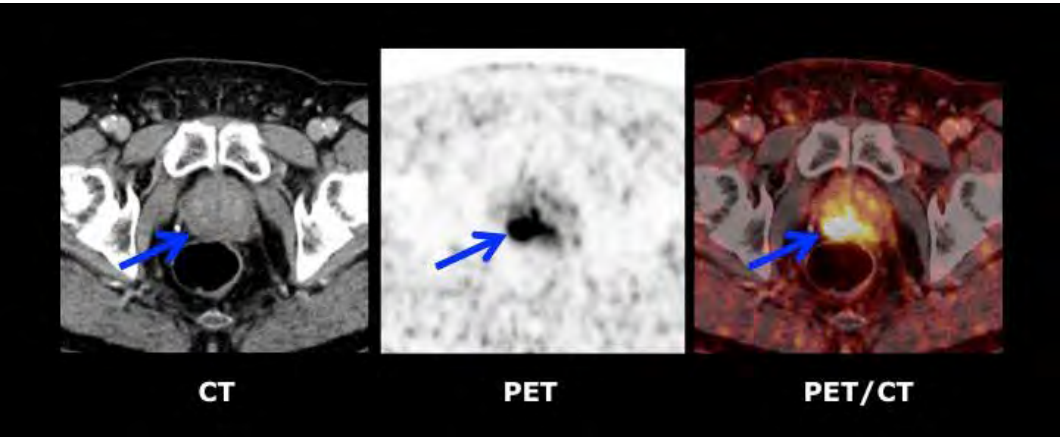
Figure showing first-in-humans uPAR-PET/CT imaging in a patient with prostate cancer using the PET tracer ⁶⁴Cu-DOTA-AE105.
